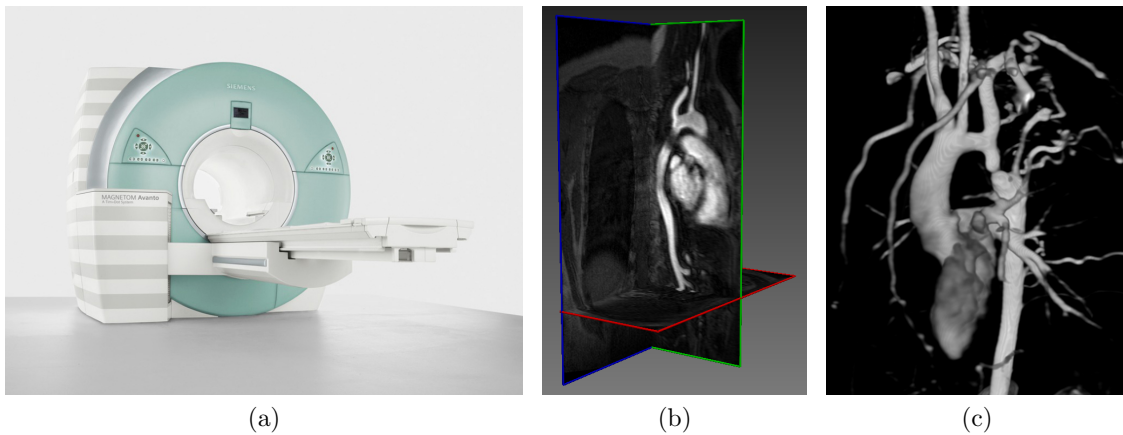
(a) Modern MRI scanner (Magnetom, Siemens, Erlangen, Germany); (b) Contrast-enhanced MR angiogram (CE-MRA); (c) Volumetric reconstruction of 3D cardiac MRI, showing the aortic arch and surroundings in presence of CoA.
